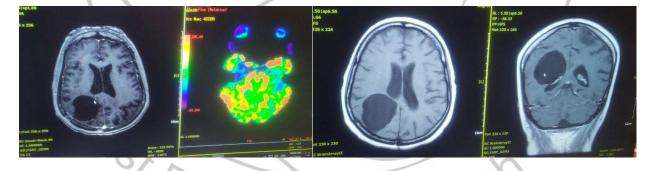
Brain MRI shows masses postsurgical site.
